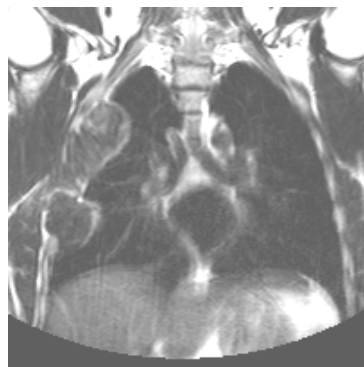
Chest X-ray and Magnetic resonance images showing a local recurrence (top: 16.01.2003; left: 14.02.2003; right 07.05.2003)<sup>[19]</sup>
